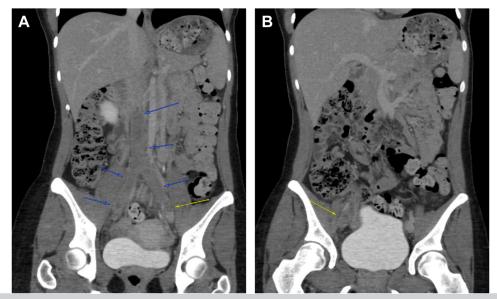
Computed tomography venography demonstrated extensive thrombosis of the suprahepatic and distal inferior vena cava (IVC) and bilateral common iliac veins (A; *blue arrows*), with extension of the thrombus into the internal and external iliac and common (B; *yellow arrows*), superficial and deep femoral veins all the way to the right proximal thigh.
